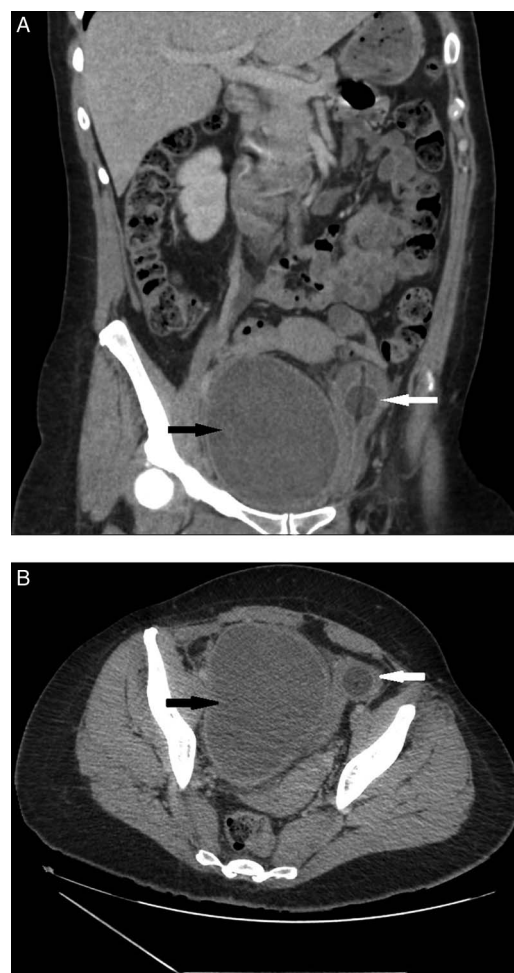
(A) Postprocedure CT scan showing haematoma on right side (black arrow) and the bladder on the left (white arrow). (B) CT scan showing haematoma (black arrow) and catheterised bladder with balloon (white arrow).
